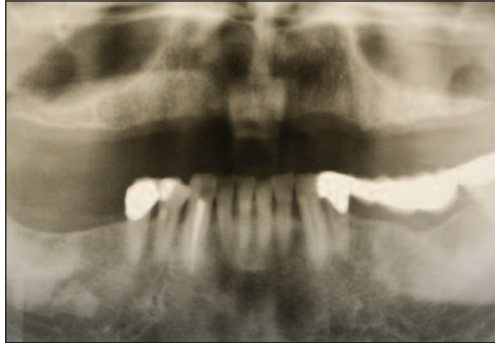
Panoramic radiograph of the patient's edentulous maxilla.
